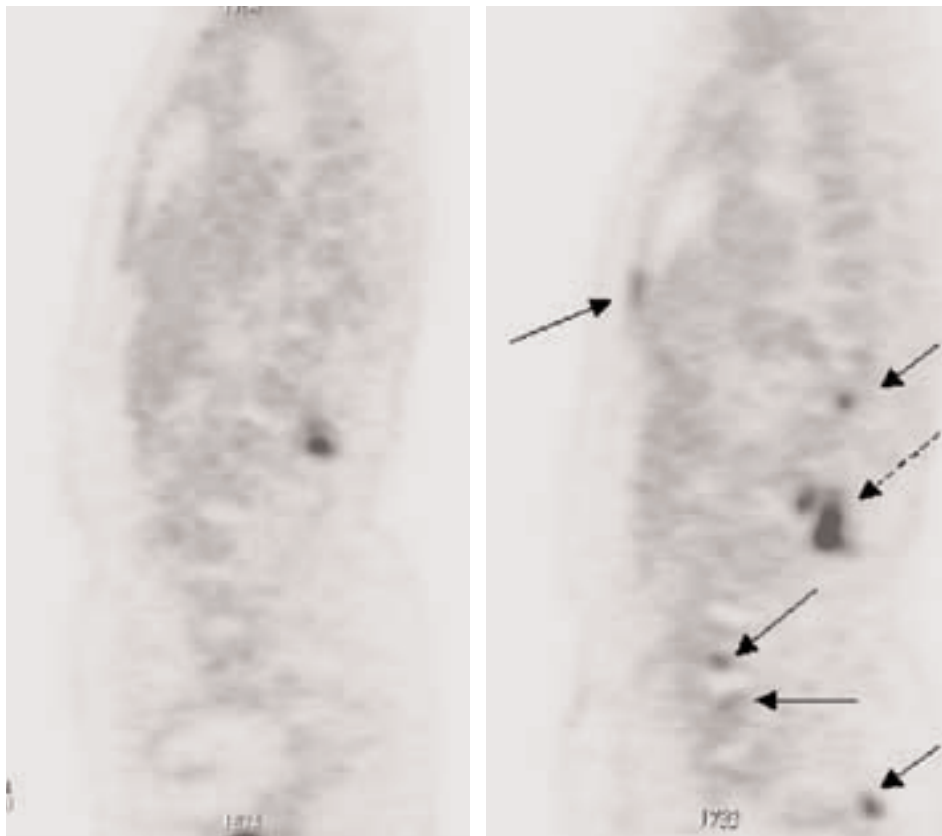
New lesions are shown in osseous structures (solid arrows) on sagittal PET image, with worsening of activity in previous T12 vertebral body metastasis (broken arrow) following a change in chemotherapy regimen. PET/CT helped to show that change in treatment was not effective.
